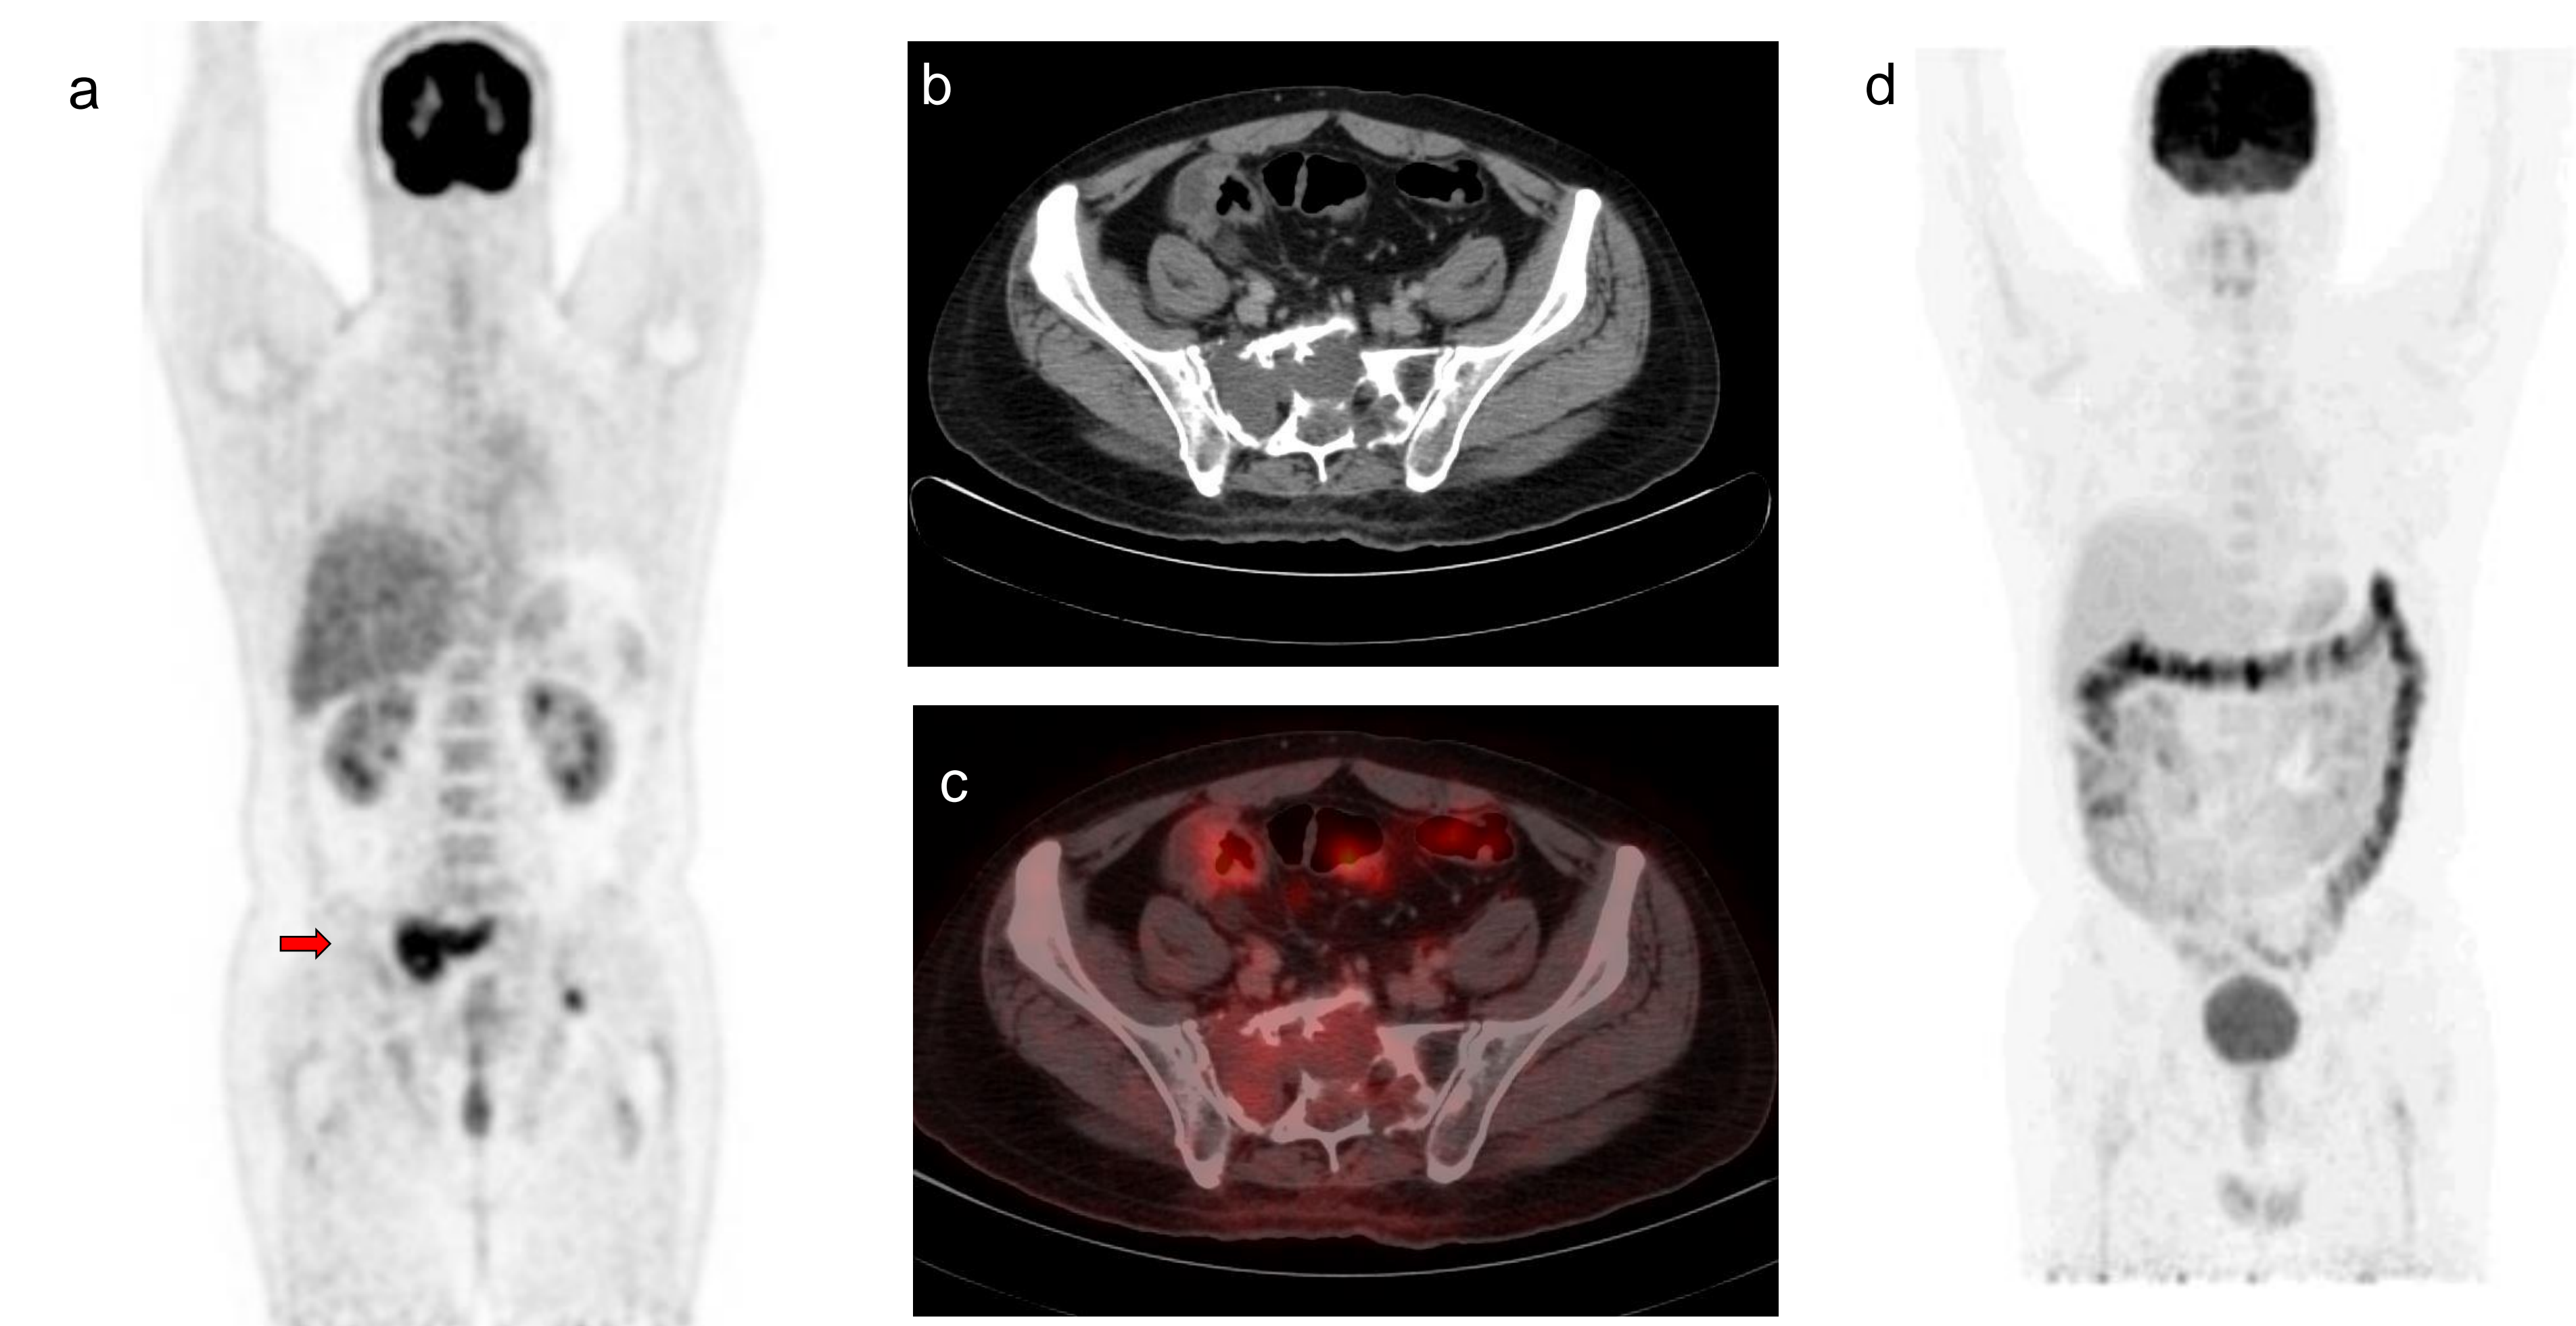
A 48 year old male with sacral plasmacytoma. MIP image(a) of the staging scan shows hypermetabolic primary sacral tumour (red arrow). Re-staging scan of the same patient: CT only image (b) shows morphological presence of the primary sacral tumour; Fused PET-CT image (c) and coronal MIP image (d) shows no metabolic activity, suggestive of Complete Metabolic Response.
